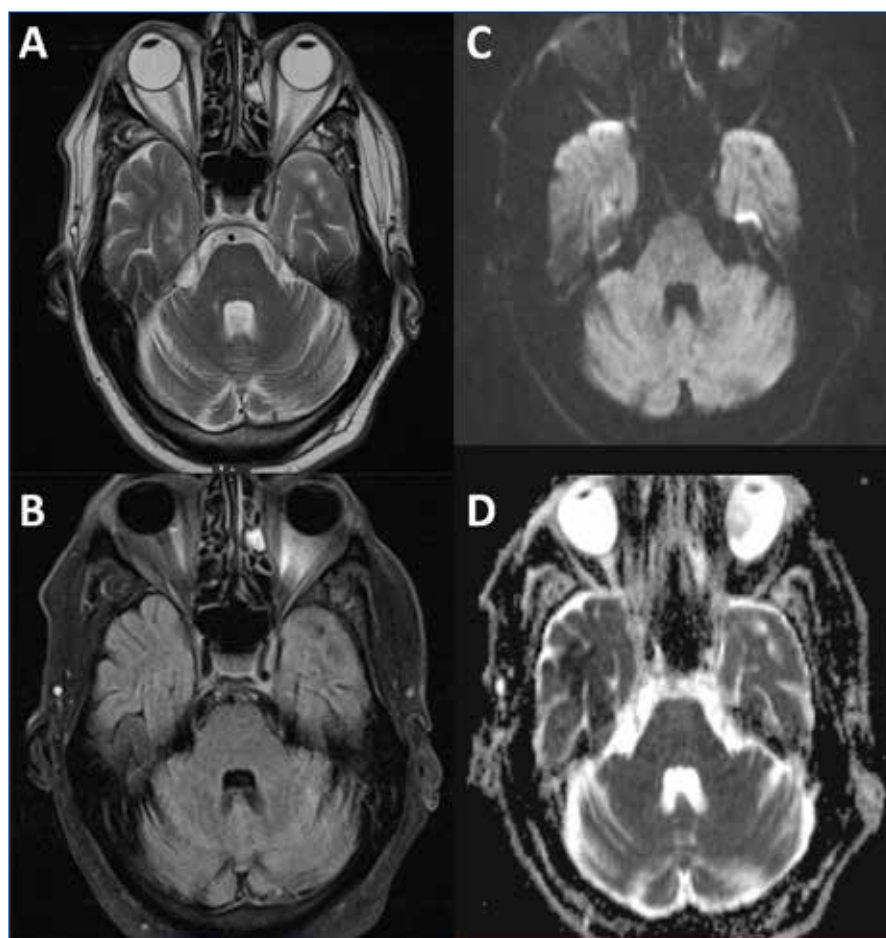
Magnetic resonance imaging (MRI) of the cerebrum. Subtle T2/FLAIR hyperintense signal in the pons (A+B), which corresponds to a small area of diffusion restriction (C) with signal loss on the apparent diffusion coefficient (ADC) image (D).
